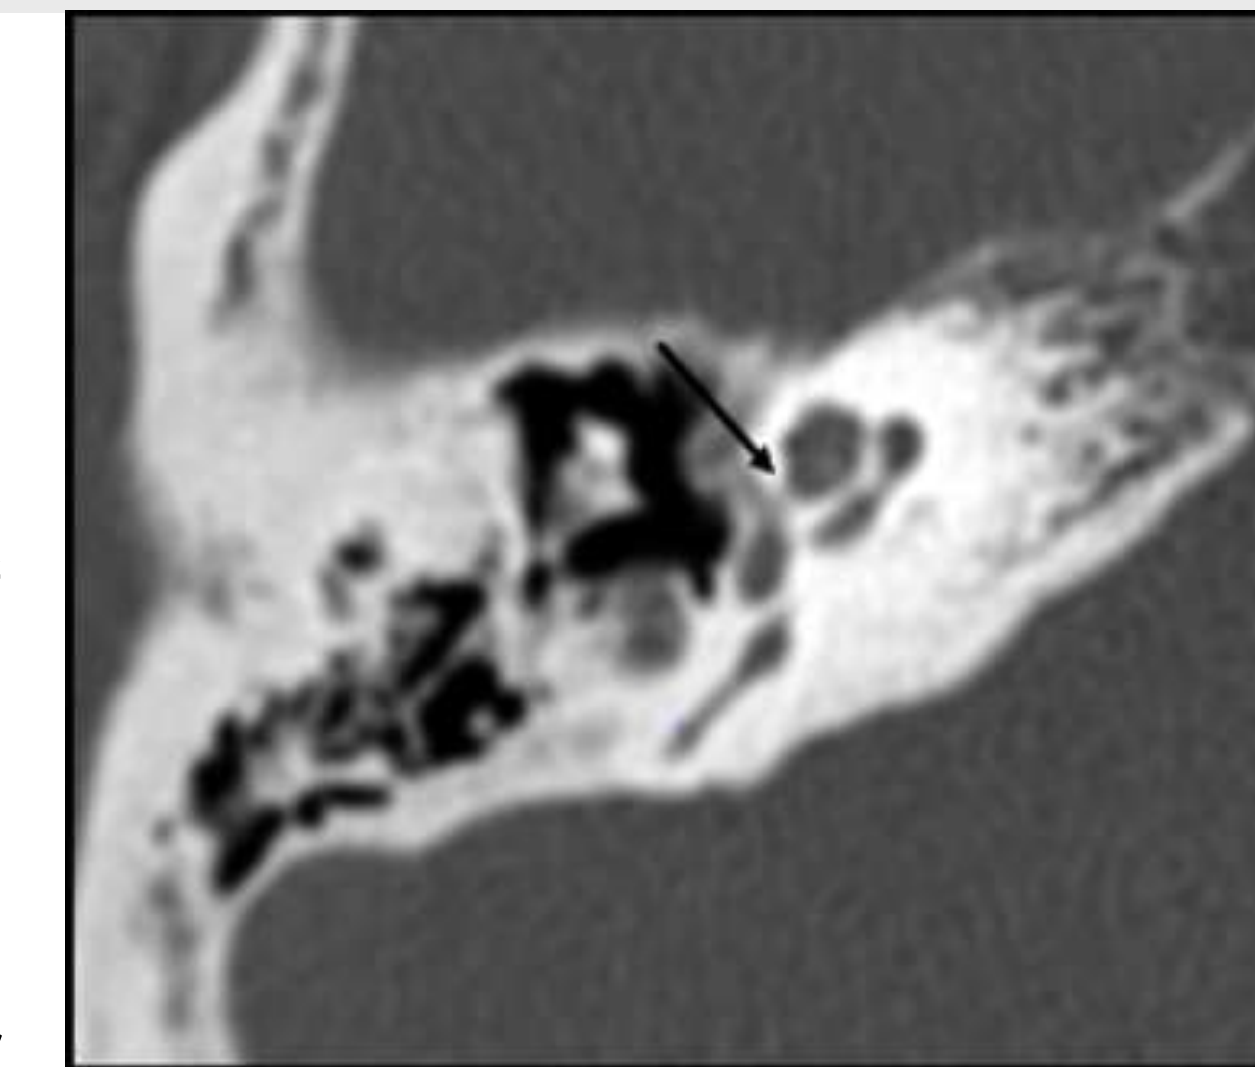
CT scan of the right temporal bone in axial section showing a type III otospongiosis focus, associated with an endosteal breach (Arrow).
